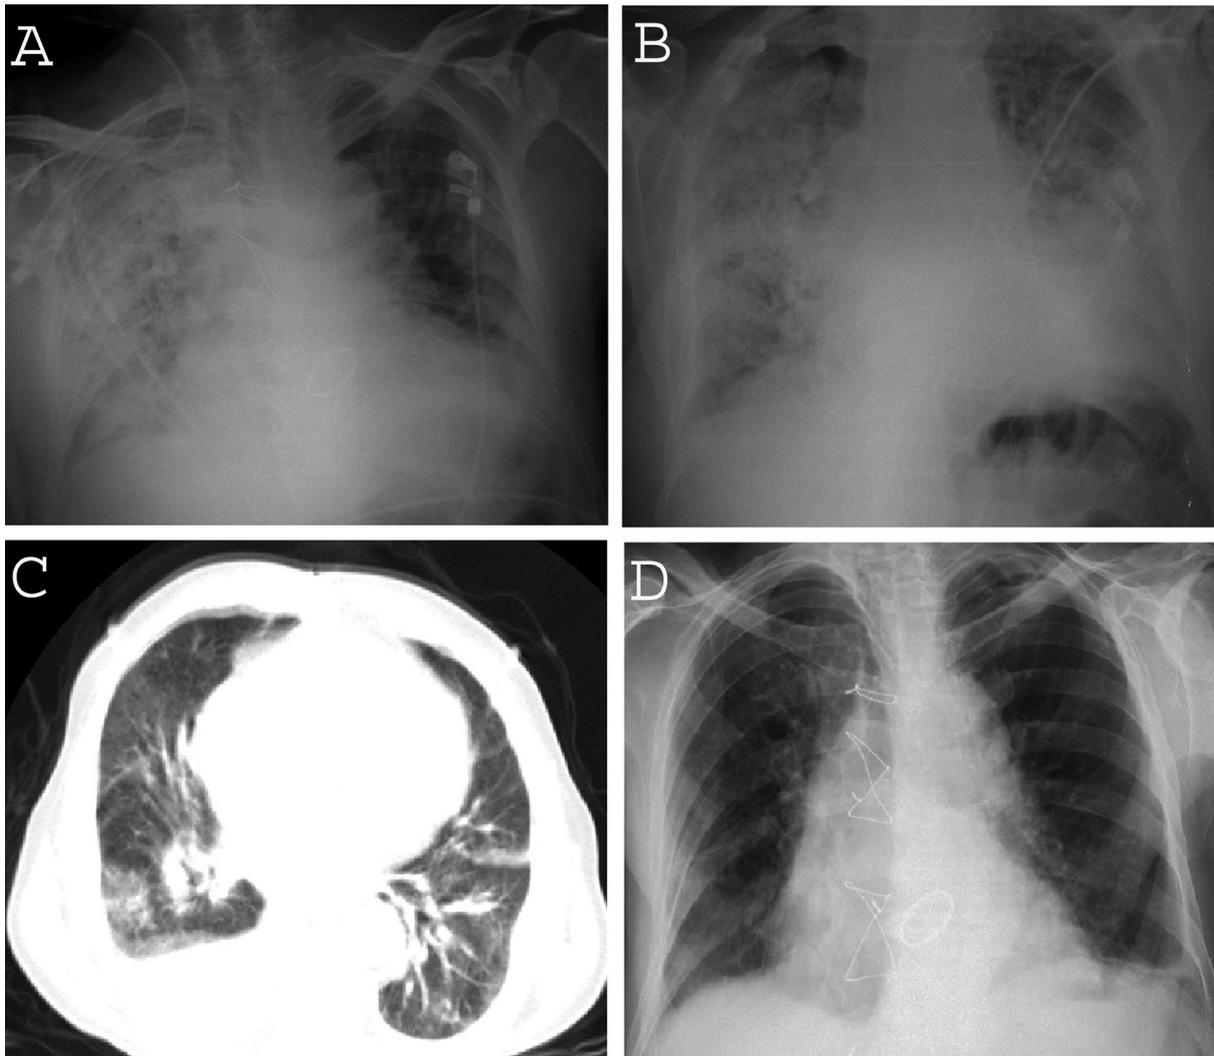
Chest X-ray shows the new infiltration areas especially on the right side (Figure 1A). The patient's clinic did not improve and the parenchymal opacity progressed in the chest X-ray (Figure 1B). CT scan demonstrated diffuse ground glass opacities involving bilateral lungs and pleural effusion on the right (Figure 1C). Pulmonary infiltration disappeared Chest X-ray (Figure 1D).
